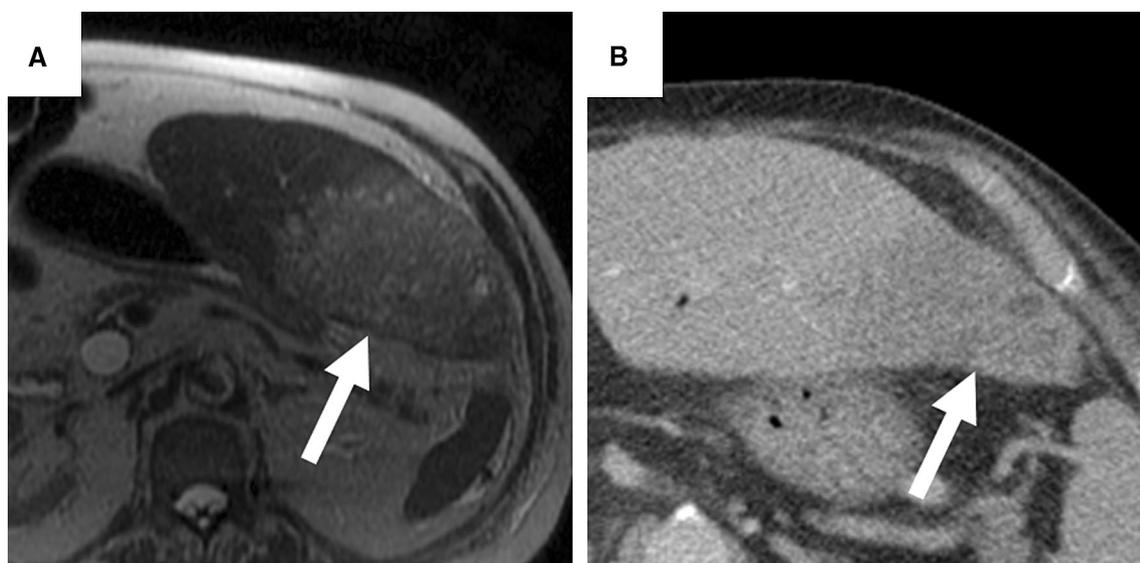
Patient with hepatitis B underwent a right hepatectomy several years prior for HCC. She was presented subsequently with symptoms of sepsis and MRI revealed a geographic, infiltrative area of signal abnormality in the left lobe of the liver (A, arrow). In view of the history of hepatitis B infection, the possibility of an underlying infiltrative
